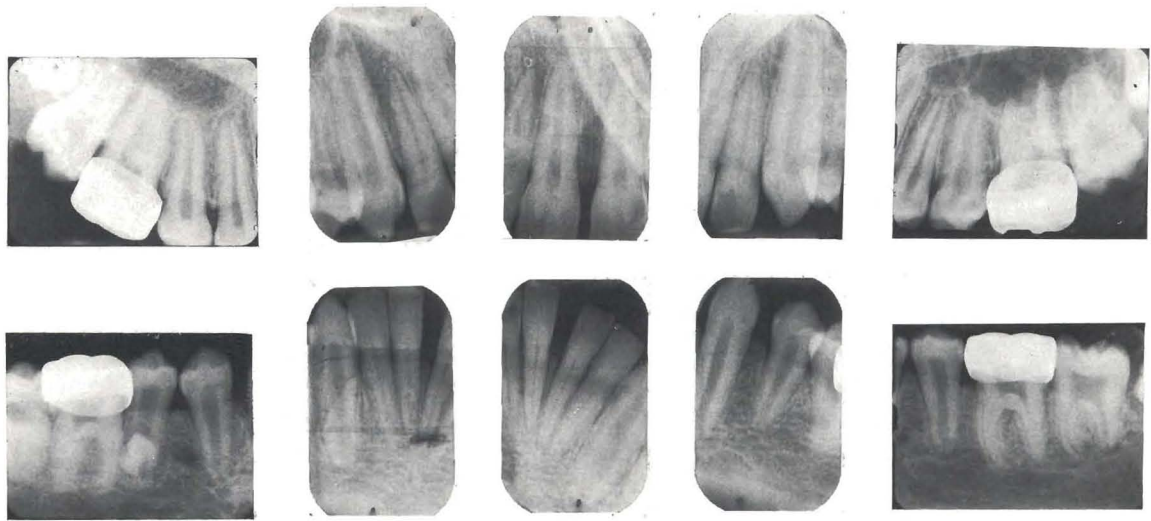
Radiographs showing normal dental anatomy of patient at age twelve.
